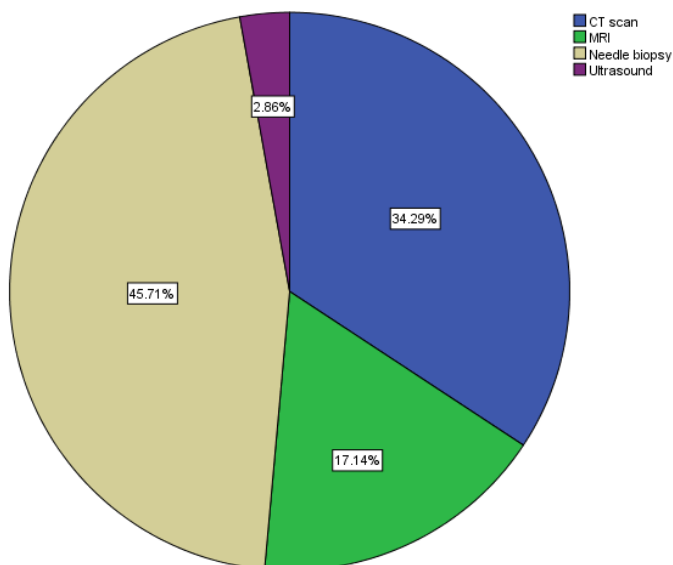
Pie chart representing percentage distribution of responses about awareness on diagnosis of liver cirrhosis, 45.71 % - needle biopsy (grey), 34.29 % CT scan (blue), 17.14 % - MRI (green), 2.86 % - ultrasound (violet)
